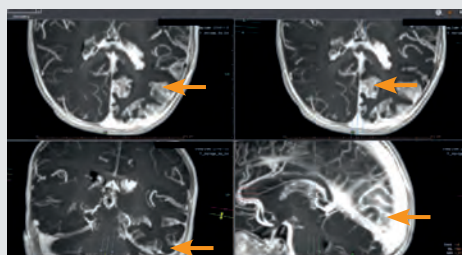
MRI performed on a 9-month baby girl - MIP reformation from 3D T1 post Gadolinium
